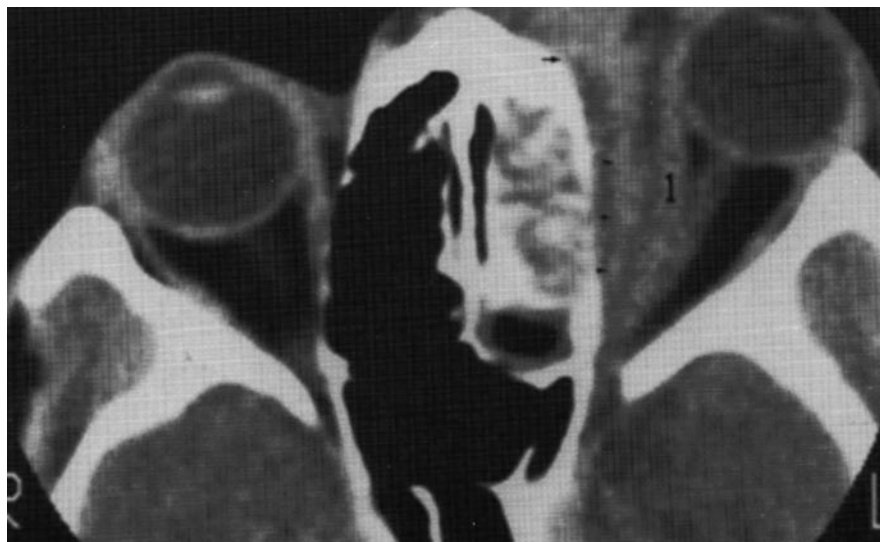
Ossifying fibroma. A coronal computed tomographic scan showing a large ossifying fibroma (*arrows*).
